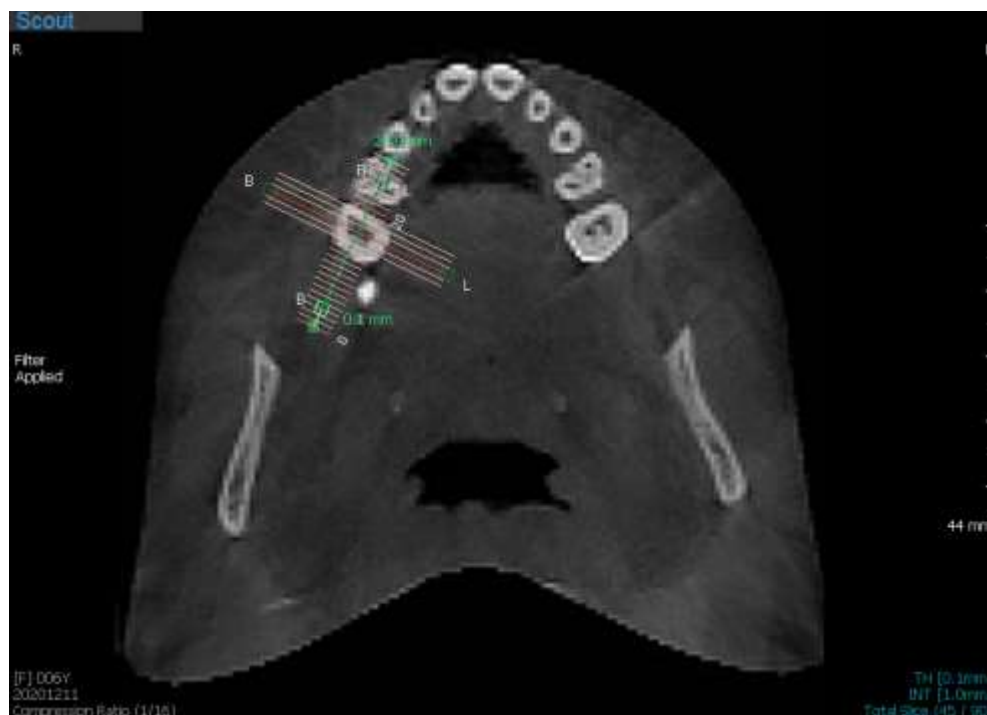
Axial CBCT section of primary maxillary right second molar.
